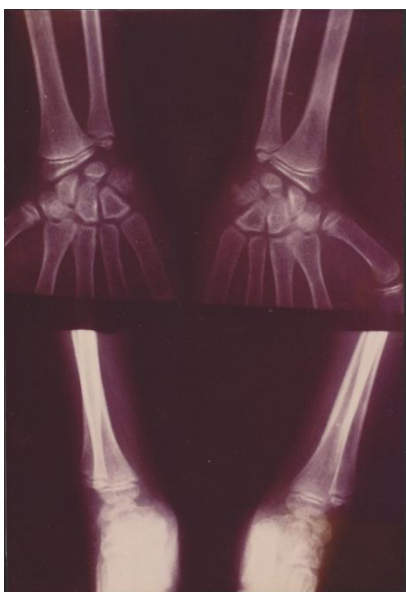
X-rays of the hand performed for bone aging revealed an age of 10 years by Greulich and Pyle method
